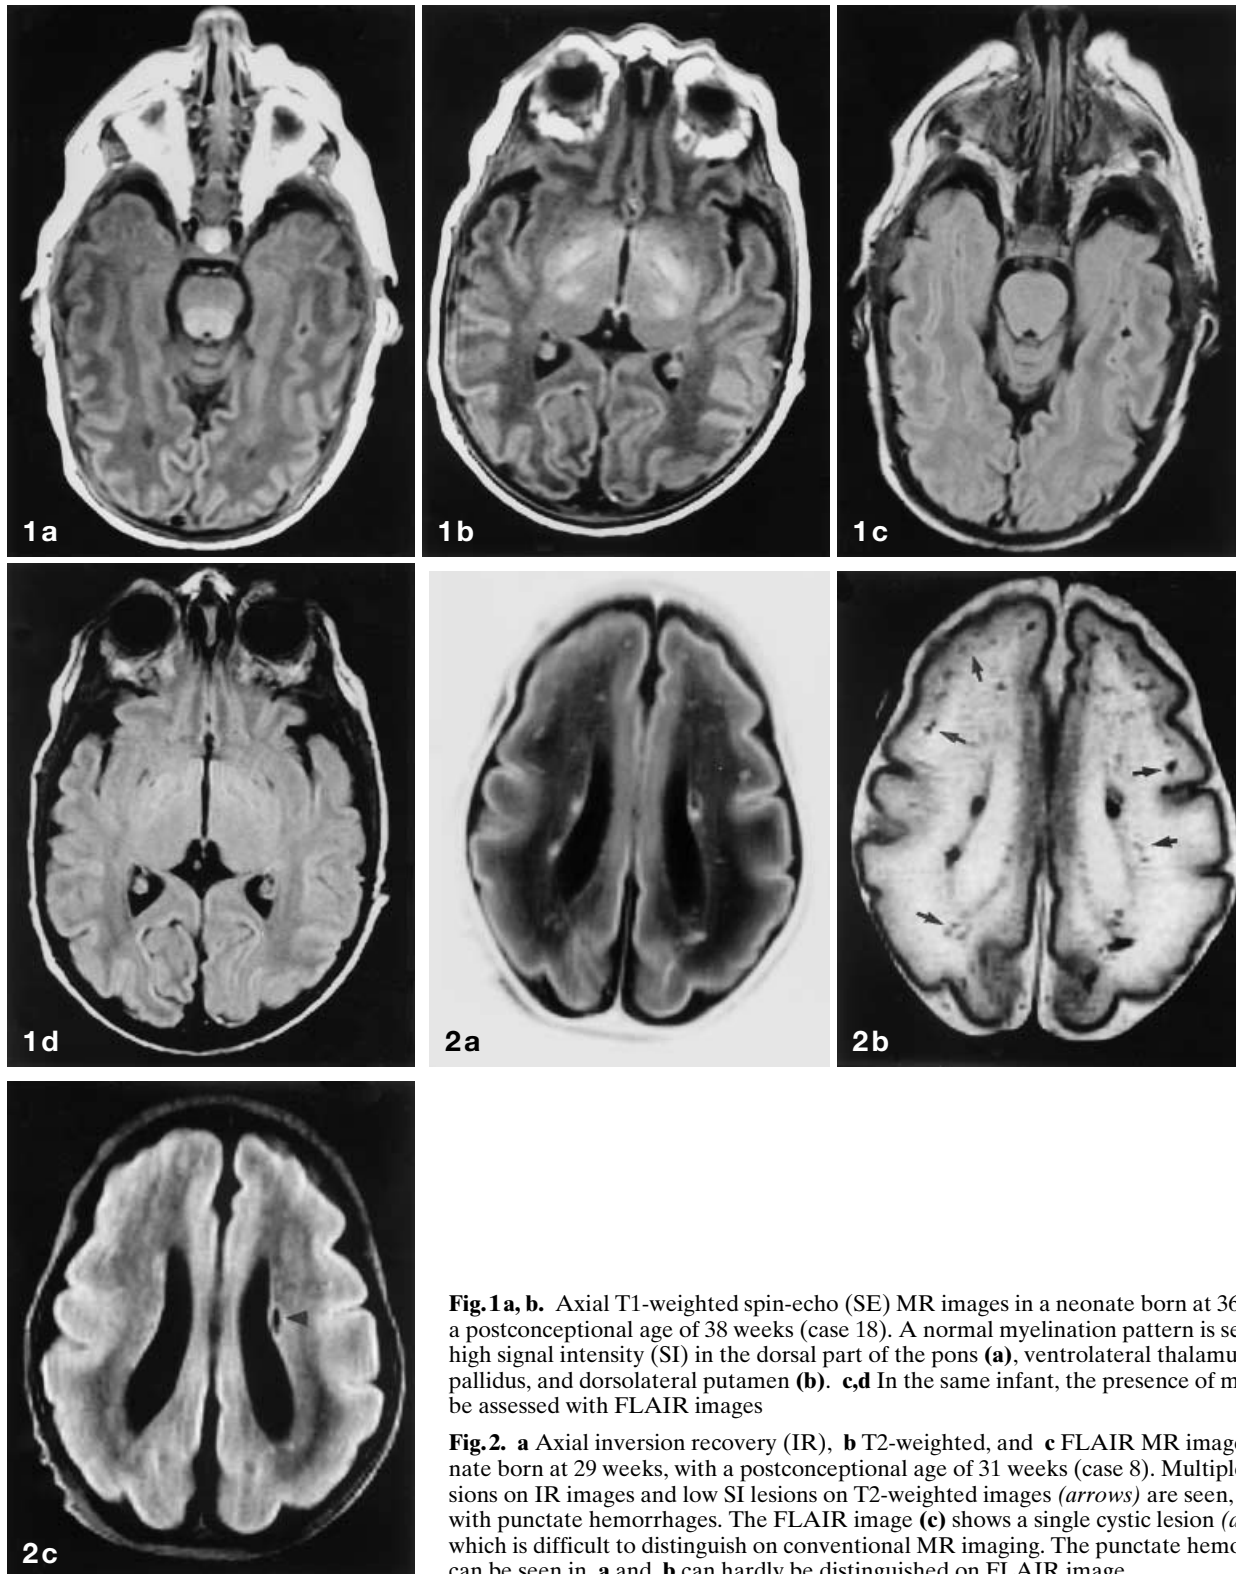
a, b. Axial T1-weighted spin-echo (SE) MR images in a neonate born at 36 weeks, with a postconceptional age of 38 weeks (case 18). A normal myelination pattern is seen, with a high signal intensity (SI) in the dorsal part of the pons (a), ventrolateral thalamus, globus pallidus, and dorsolateral putamen (b). c,d In the same infant, the presence of myelin cannot be assessed with FLAIR images
